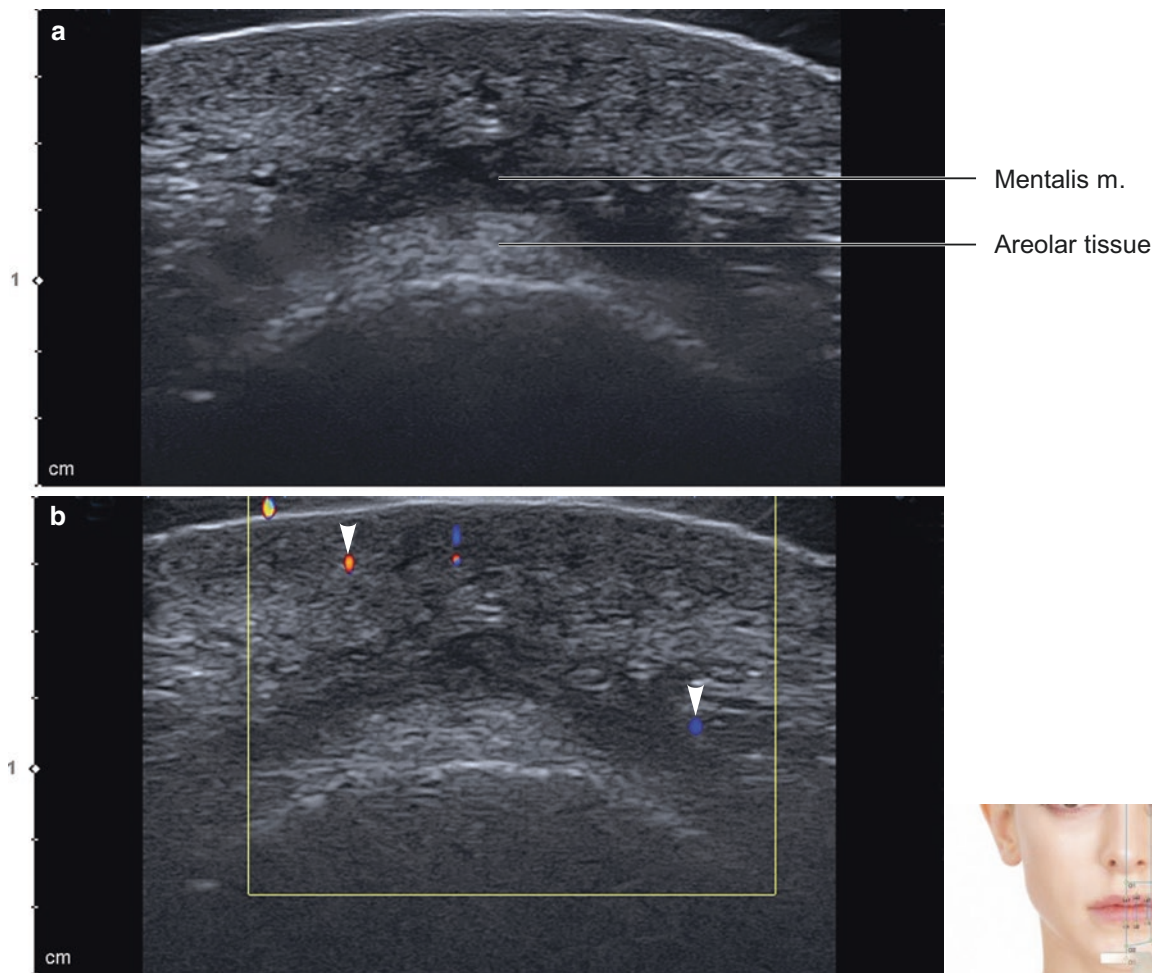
Ultrasonography of the pogonion (O3). (a) B mode (transverse view, 15 MHz by linear transducer) and (b) Doppler mode (transverse view, 15 MHz by linear transducer) (arrowheads: cutaneous
